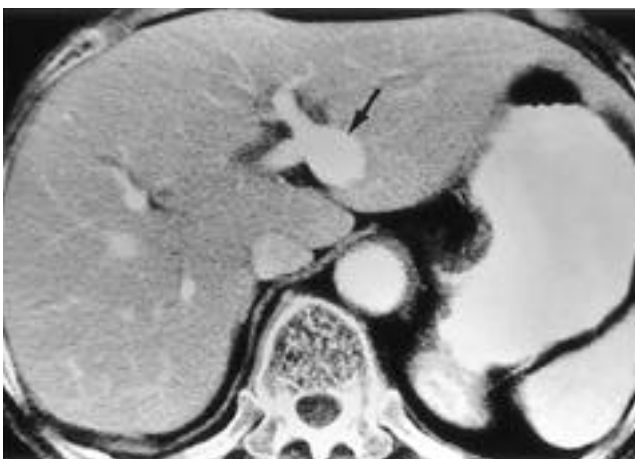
82-year-old woman with intrahepatic portal vein aneurysm. Portal-venous phase helical CT scan shows a saccular dilatation of portal vein at between the transverse and umbilical portion of the left portal vein (arrow).
